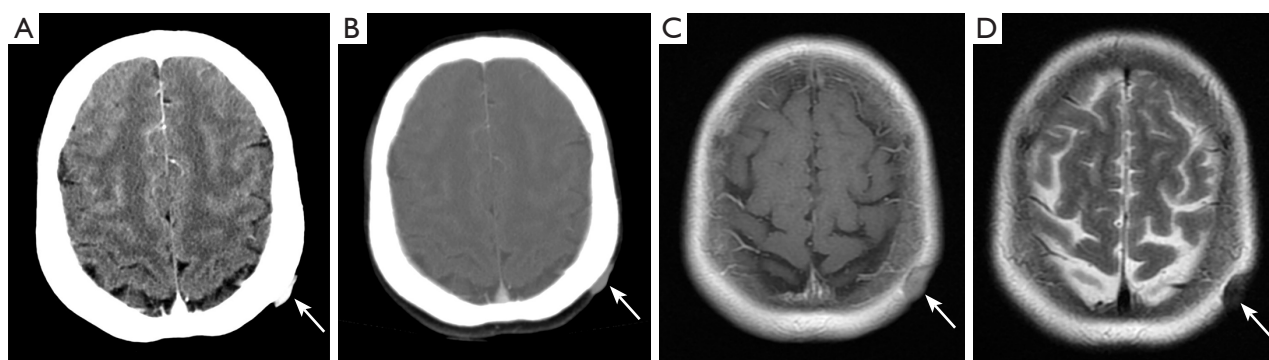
Blind spot in brain imaging: scalp. Scans of a 53-year-old female with multiple bone metastases, who had undergone therapy for breast cancer 5 years ago. No apparent metastases were observed in the brain parenchyma; however, radiologists missed a soft-tissue density nodule in the left scalp on CT scans (arrows) (A,B), which was more apparent on MRI images (arrows) (C,D). Subsequently, a biopsy of this nodule confirmed malignancy. Taking the patient's medical history into consideration, this nodule was highly suggestive of a metastatic lesion from breast cancer. CT, computed tomography; MRI, magnetic resonance imaging.
